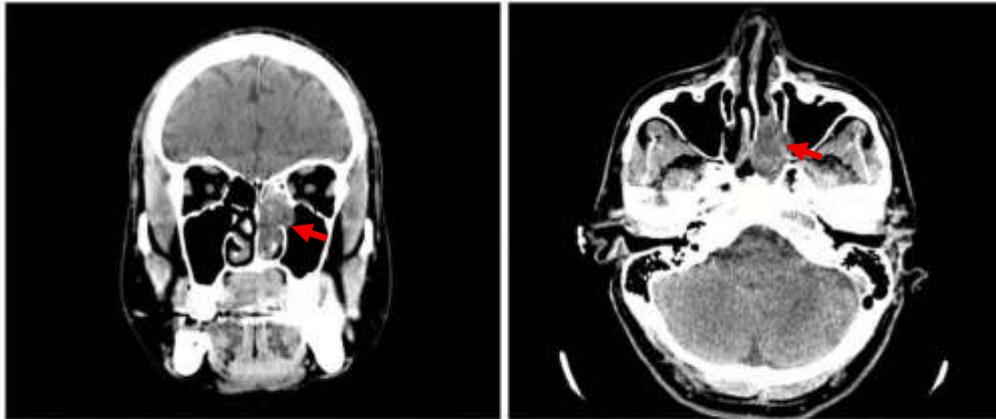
Non-contrast cranial CT scan shows a solid-density mass occupying zones IV and V of the left nasal cavity, with extension into the nasopharynx.
